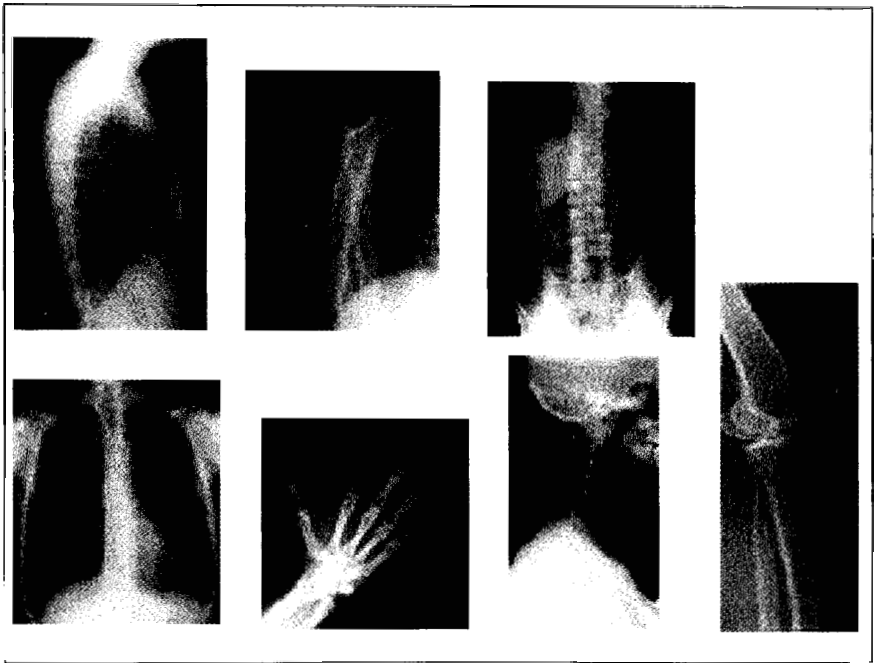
Clinical X-ray images showing the potential of commercial a-Si indirect Digital Radiography system (Images from Evergreen Hospital Medical Center, Kirkland, WA, USA) [55]. Top row: chest side, arm, abdomen; bottom row: chest, hand, head, knee.
